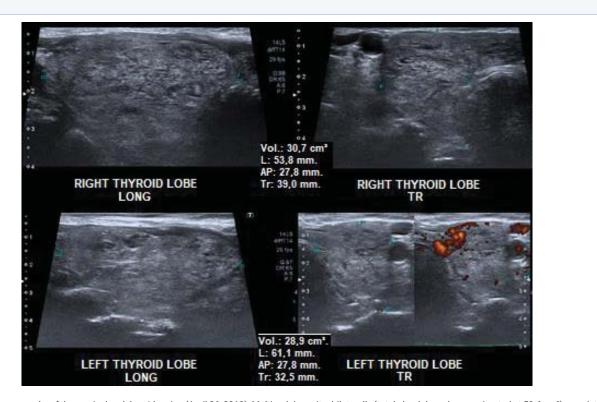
Ultrasonography of the cervical and thyroid region (April 26, 2019): Multinodular goiter bilaterally (total glandular volume estimated at 59.6 cm<sup>3</sup>), consisting of predominantly solid isoechoic nodules, American College of Radiology Thyroid Imaging Reporting and Data System 3 (ACR TI-RADS 3) and low risk (American Thyroid Association, ATA, 2015).
